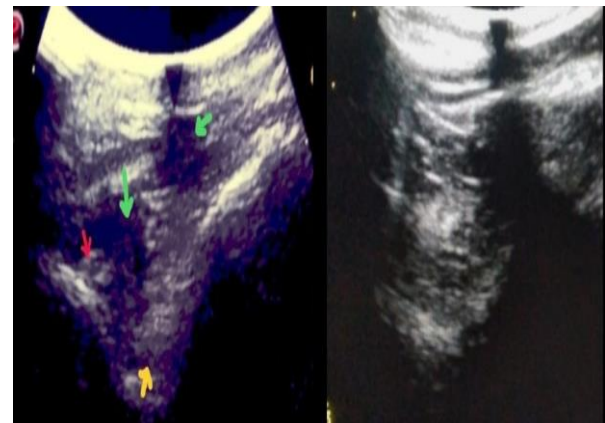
Ultrasonography of the maxillary paranasal sinuses shows tissue threads (green arrows), the radiological pathognomonic “Eye Sign” of *H. pylori* (red arrow), and thread aggregation forming a mass (yellow arrow) in the left image, while the right image depicts the sinus cavity filled with a dense mass of clustered tissue threads.
